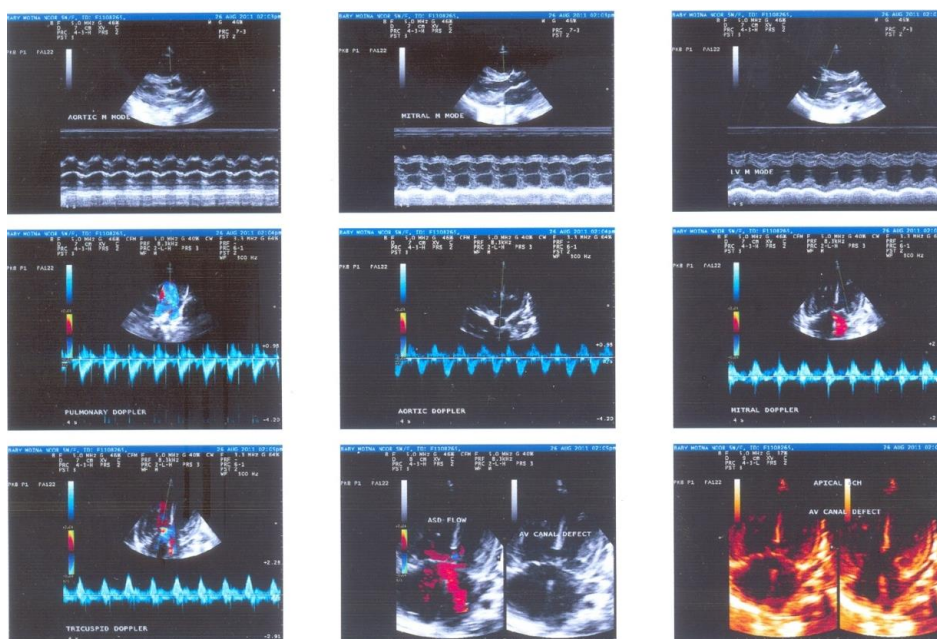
Echocardiography showing AV canal defect with Left to Right shunt
